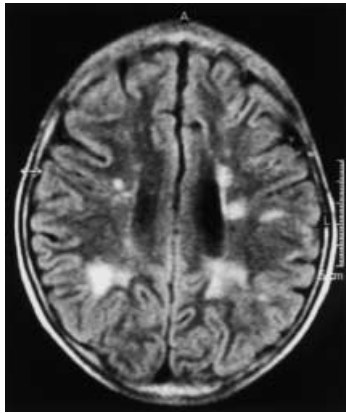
Diffuse lesions. Predominantly patchy and ill-defined lesions of the supratentorial periventricular white matter on fluid-attenuated inversion recovery (FLAIR) images in a 9-year-old boy and a follow-up of 1.5 years after surgery and combined chemo-/radiotherapy of a medulloblastoma
